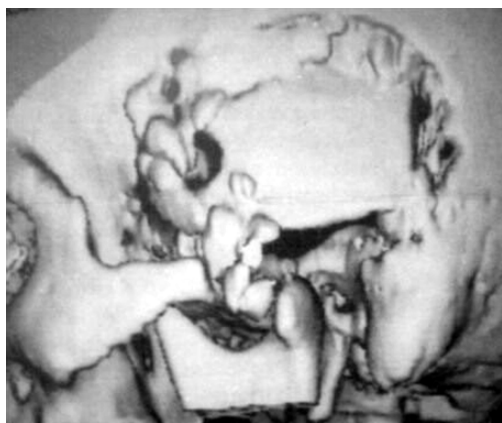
Post-operative three-dimensional CT image showing removal of the posterior aspect of the zygomatic arch, roof of the condyle and the external ear and the superior part of the mastoid air cells. The basal exposure available to the petrous apex can be appreciated
